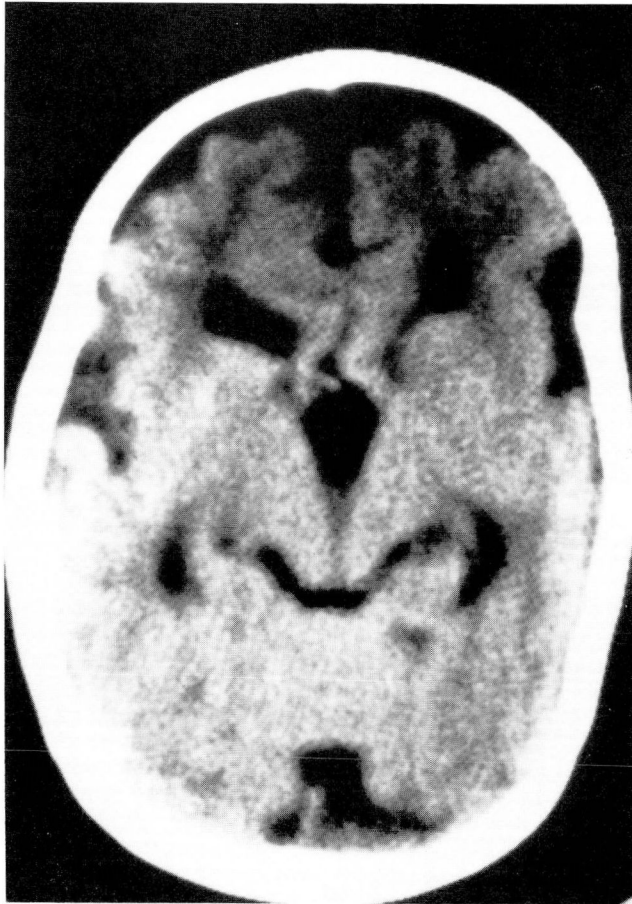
Computed tomography scan showing agenesis of the corpus callosum. There is also marked enlargement of the subarachnoid spaces surrounding the frontal lobes.
